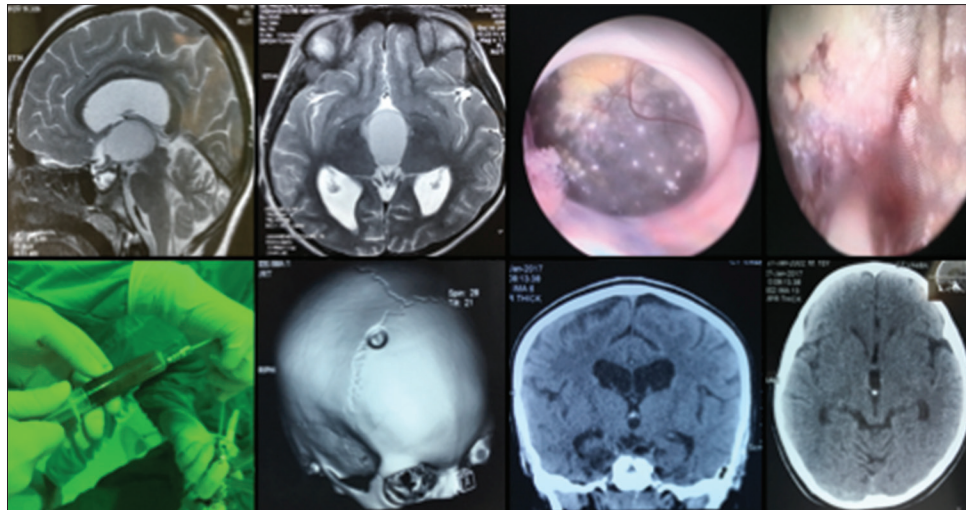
Endoscopic cystic decompression and cystocisternostomy. (Patient no 13 [Table 2]) Top row images 1 and 2 – Magnetic resonance imaging T2 images show cystic craniopharyngioma with extension to the 3rd ventricle. Top row images 3 and 4 – Endoscopic images of cystic craniopharyngioma occluding the foramen of Monro and endoscopic intracavitary image showing flecks of calcification. Bottom row image 1 – Fluid aspirated from cystic craniopharyngioma –“Machine oil.” Bottom row images 2-4 – Computed tomography images shows site of burr hole, shows decompression of cystic cavity and regression of ventriculomegaly (follow-up computed tomography at 6 months)
